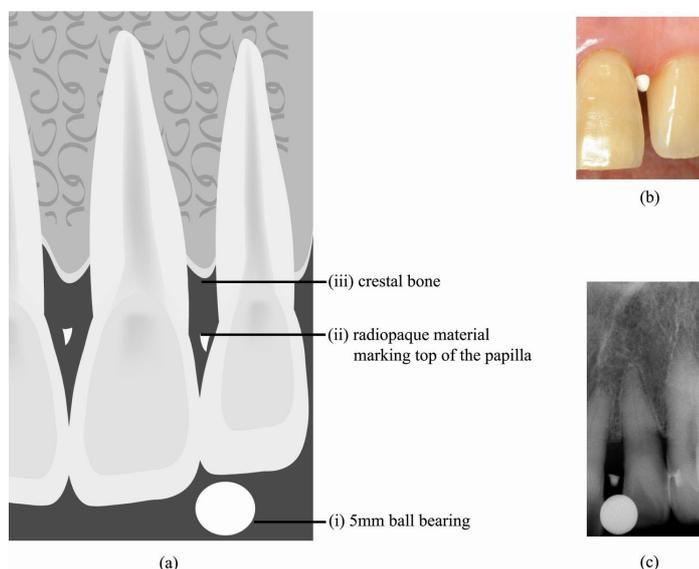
Measuring radiographic length. (a) Radiographic length (RL) is determined by measuring the distance between (ii) and (iii). (b) Clinical photo of applying radiopaque material. (c) Periapical film of (b).
